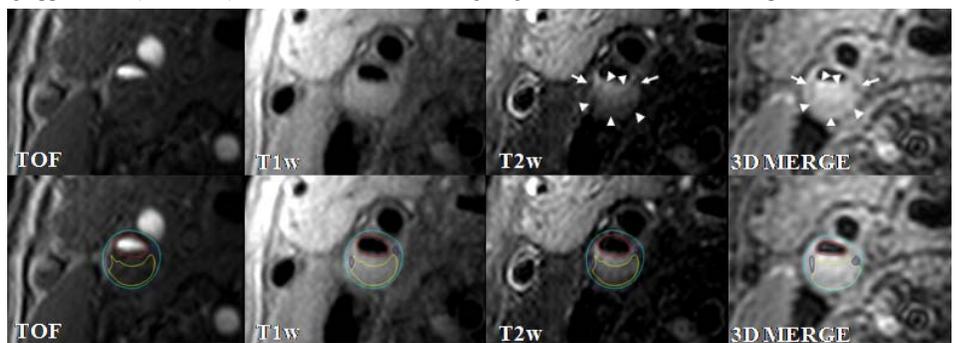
Pre- (upper row) and post-outlined (lower row) MR images showed a lipid-rich plaque in right internal carotid artery. Large LRNC (arrow head, yellow lines) appears slight hypointense on T2w image in multicontrast protocol and 3D MERGE image. Calcification (arrow, blue lines) appears hypointense on both multicontrast and 3D MERGE images. There is a good agreement between multicontrast and 3D MERGE for assessing plaque compositions.
